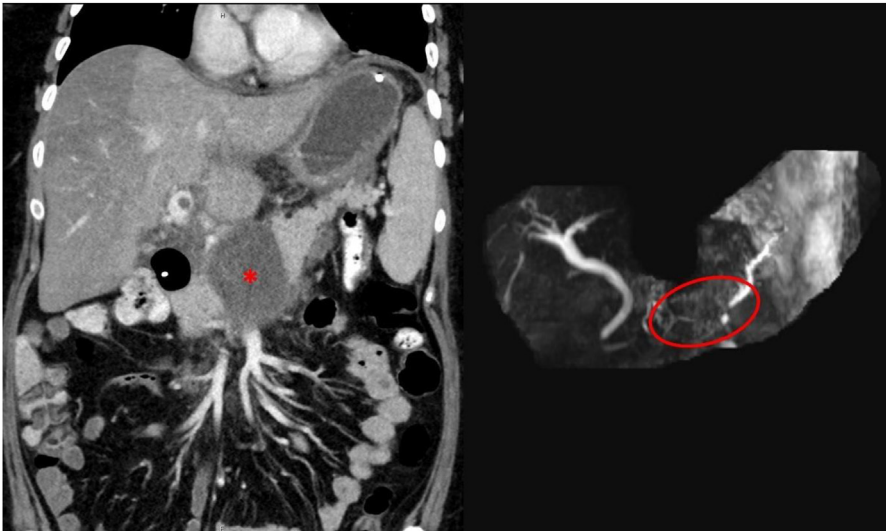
Contrast-enhanced computed tomography demonstrating necrosis involving the neck of the pancreas (*left, asterisk*) resulting in cutoff of the main pancreatic duct on magnetic resonance pancreatography (*right, ova*).
